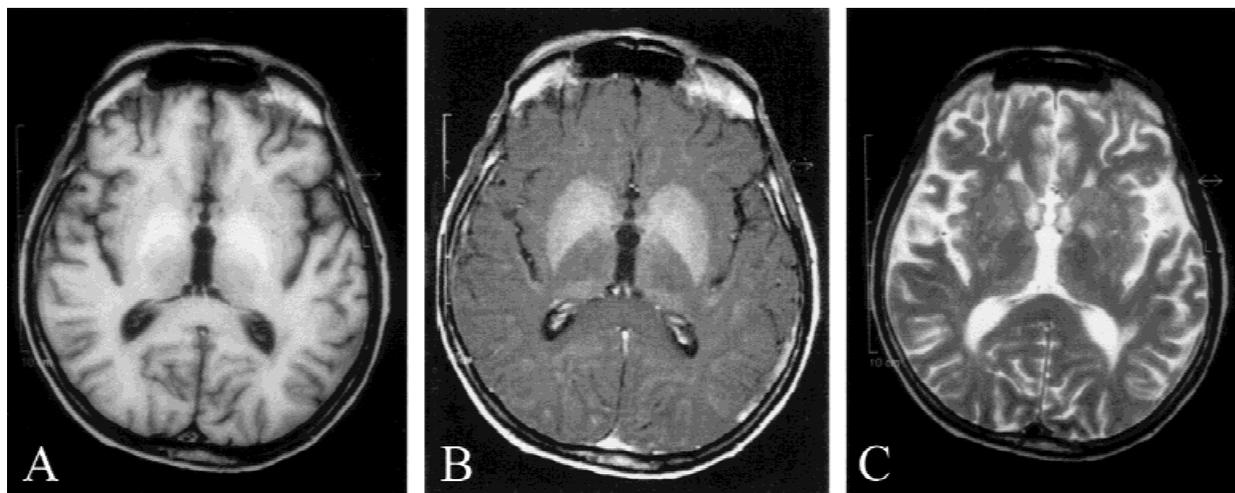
A: T_1 -weighted magnetic resonance imaging (MRI) sequences (echo time [TE], 20 msec; repetition time [TR], 550 msec) showing a bilateral spontaneous hyperintensity in the internal pallidum. B: T_1 -weighted MRI sequences (TE, 15 msec; TR, 900 msec) after gadolinium injection showing a bilateral enhancement of the hypersignal in the internal pallidum and striatum. C: T_2 -weighted MRI sequences (TE, 20 msec; TR, 2,200 msec) showing no signal abnormality in the pallidum and striatum.
